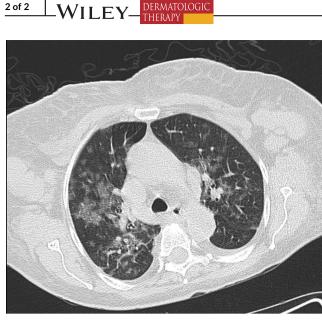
Chest computed tomography scan showing bilateral ground-glass opacities
